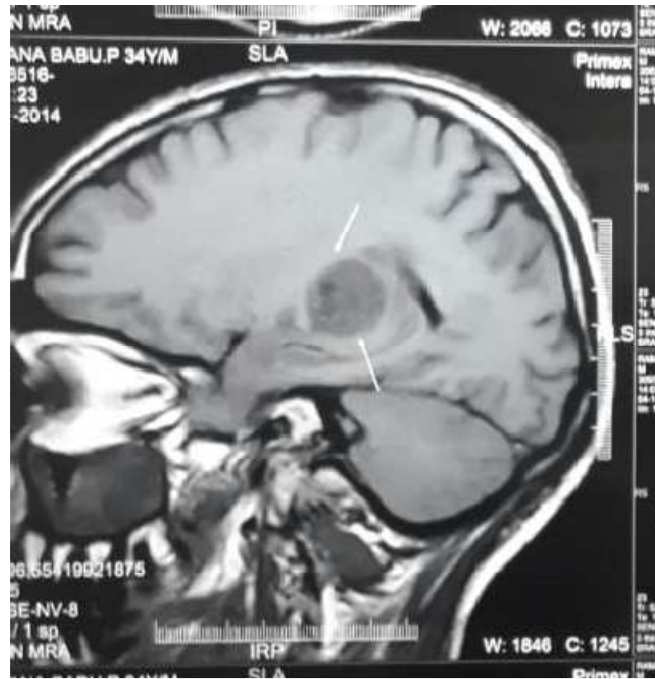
MRI PICTURE - PILOCYTIC ASTROCYTOMA
